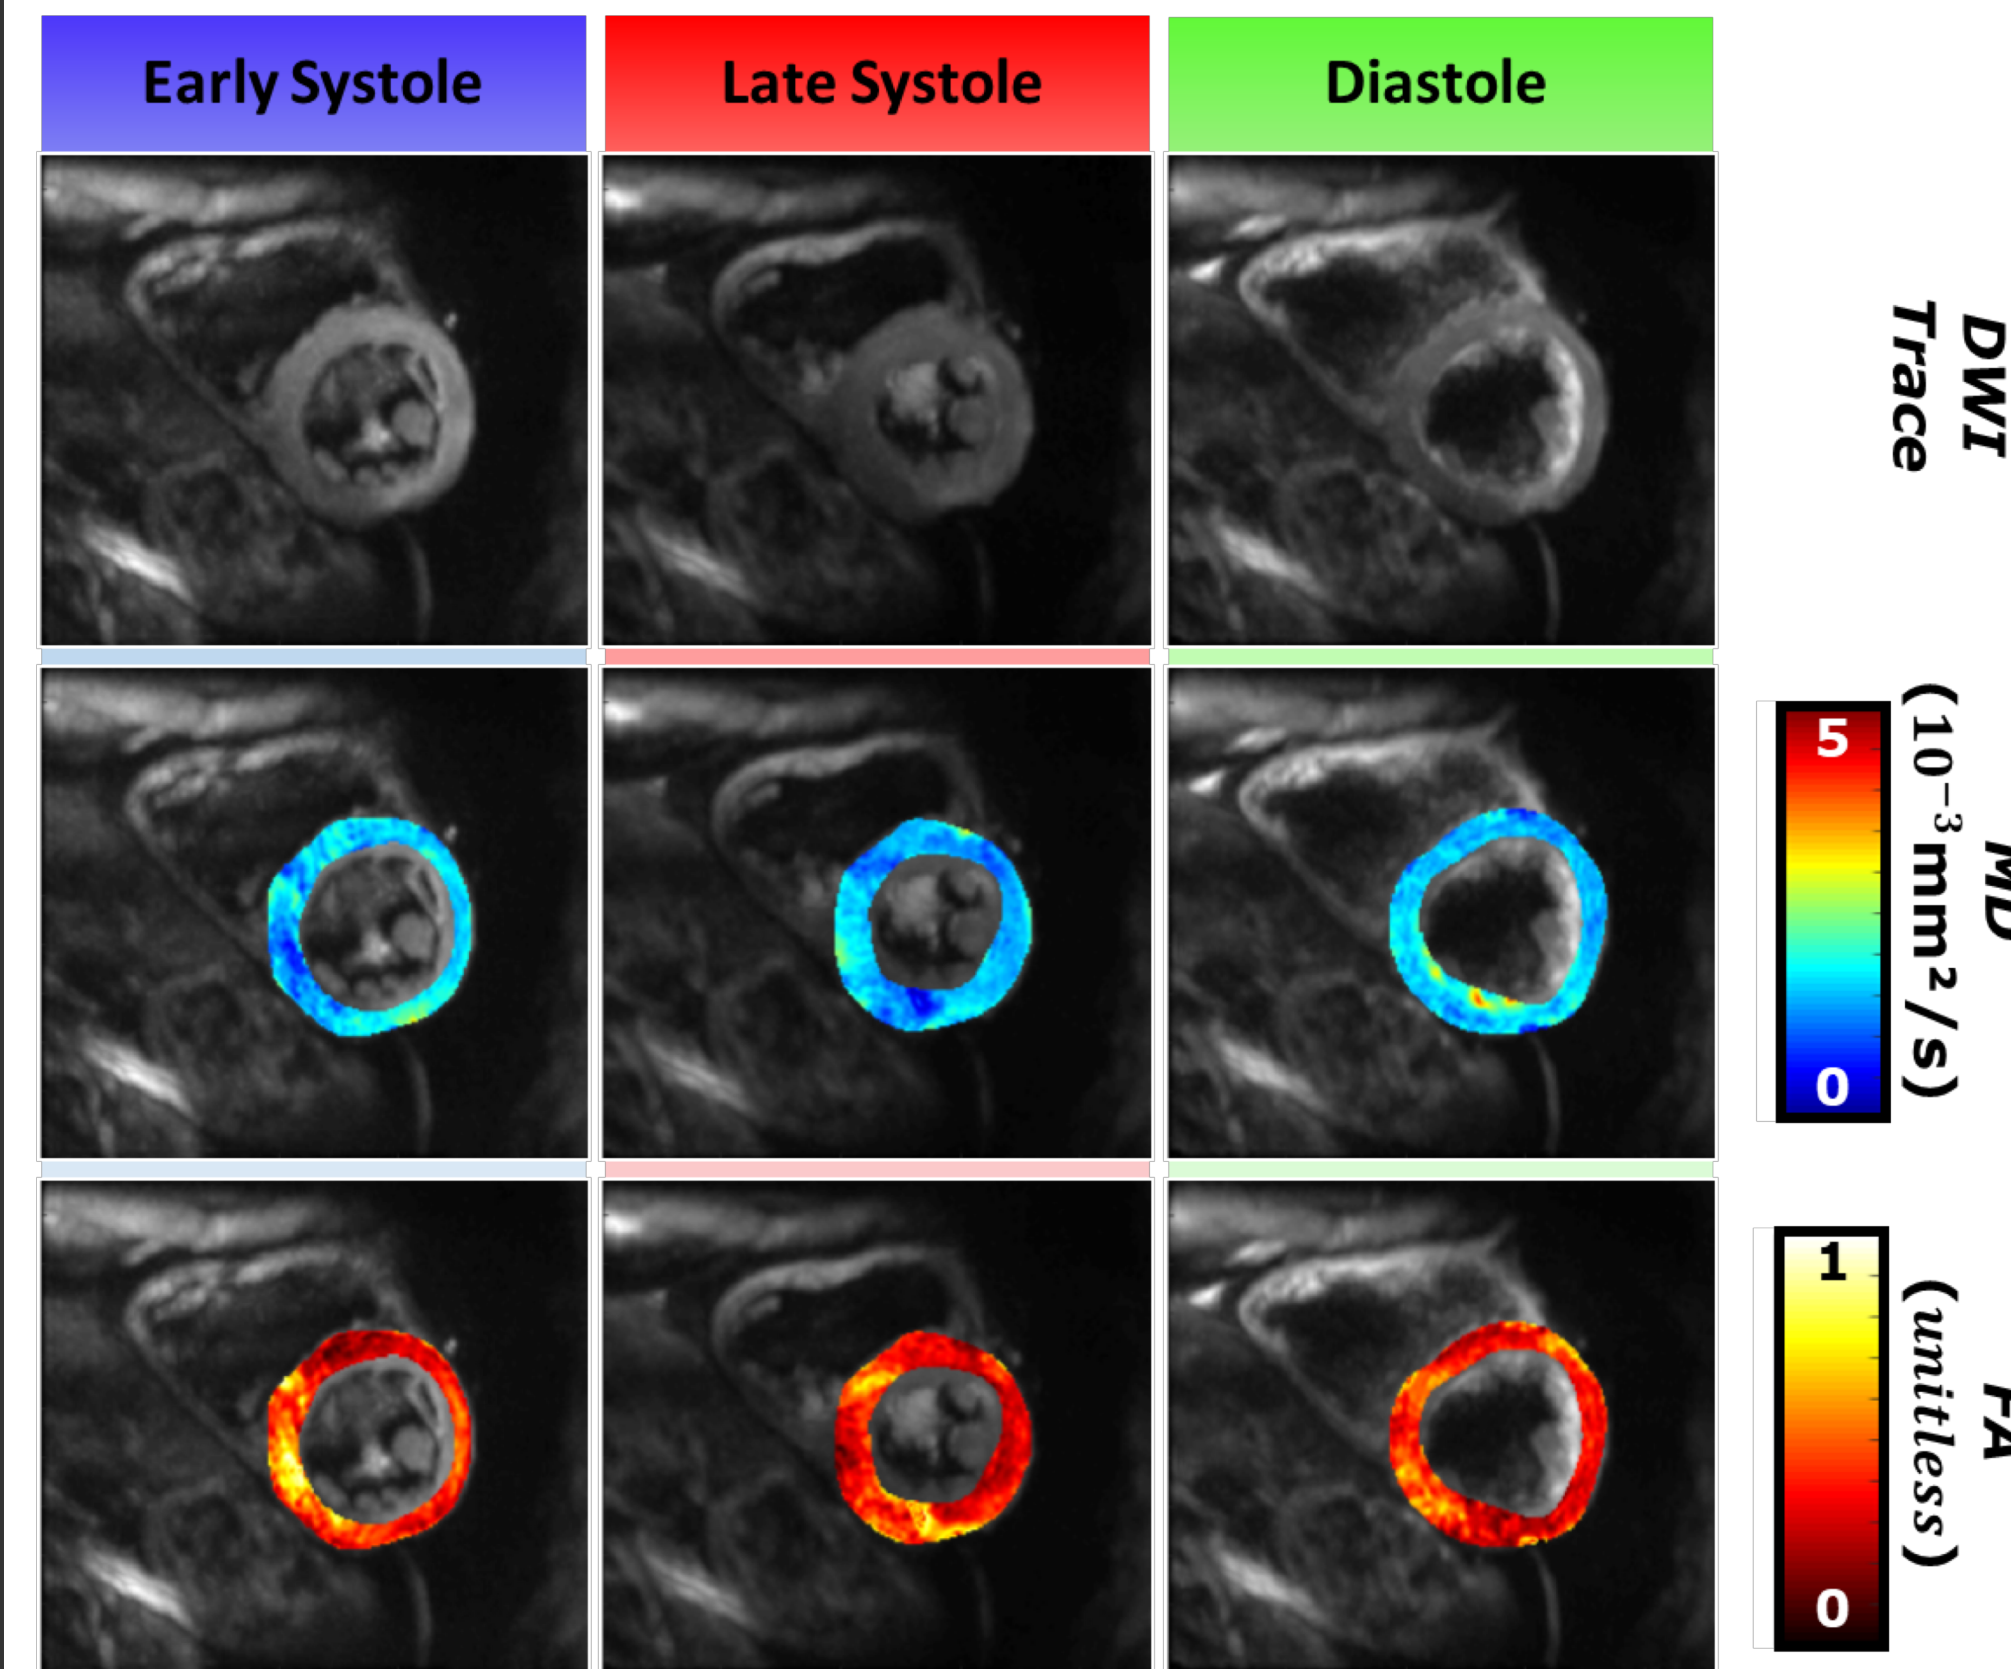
Example of reconstructed DWI Trace, MD and FA maps on one volunteer at the three cardiac phases.
